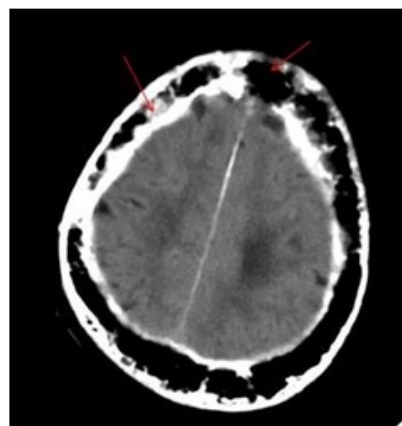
Axial CT image showing mixed lytic- sclerotic areas (red arrows) involving the bony calvarium of the skull
